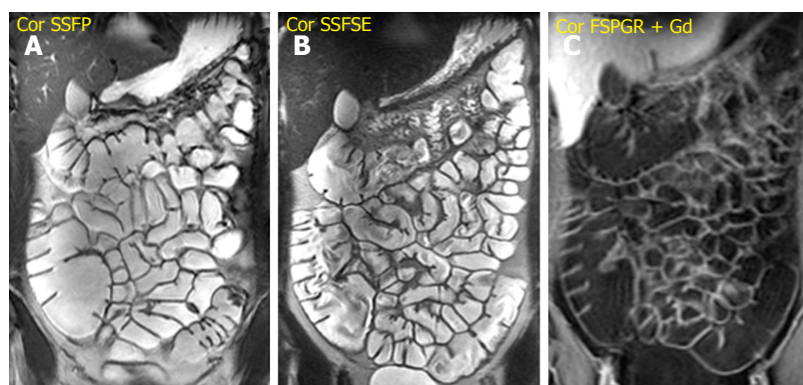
Assessment of small bowel anatomy, disease localization and segmental extension. A: Steady-state free precession (SSFP); B: T2-weighted single shot fast spin echo (SSFSE) sequence; C: Gadolinium-enhanced fat-suppressed 3D spoiled gradient-echo (FSPGR) sequence.
